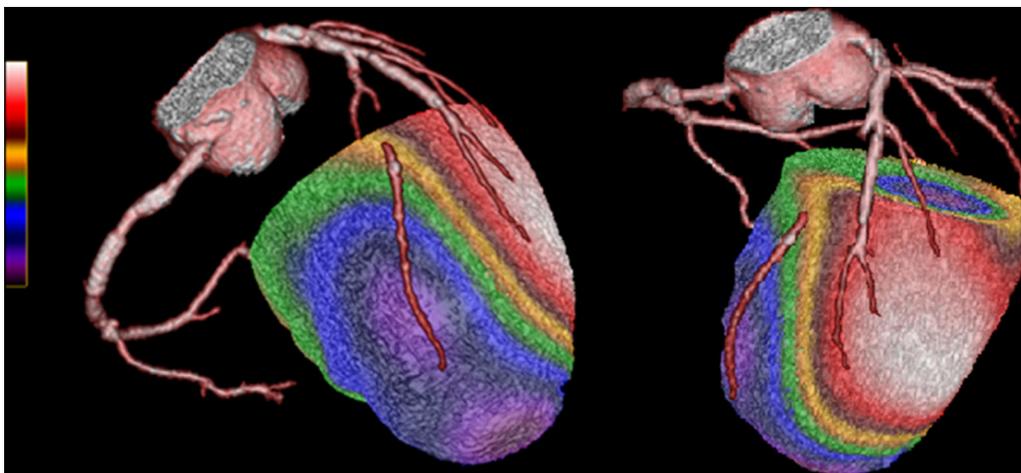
Prototypical case of hybrid anatomic-functional non-invasive imaging based on the combination of computed tomography angiography (CTA) of coronary arteries and myocardial perfusion imaging (MPI) with single-photon emission computed tomography (SPECT) in a 68-year-old gentleman with multiple cardiovascular risk factors and clinical history of effort angina. The left anterior descending is chronically occluded in the mid-segment, and there is concomitant severe ischemia in the corresponding myocardial regions. Accordingly, and in keeping with the algorithm outlined in Figure 2, invasive management is recommended. Left panel: right anterior oblique-caudal projection. Right panel: left anterior oblique-cranial projection.
